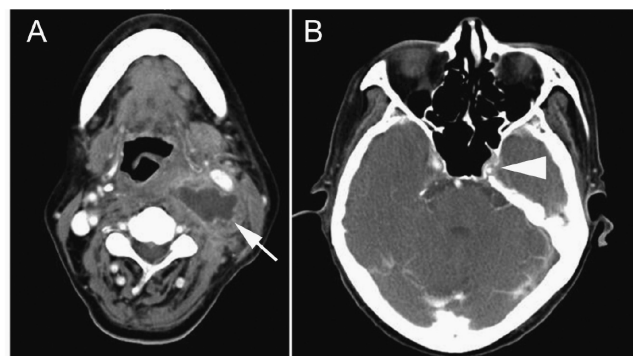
Contrast-enhanced CT image of the first examination. A : low-density, ring-enhancing mass (arrow) spread to the left carotid sheath. B : No aneurysm was seen in the sphenoid sinus (arrow head).
